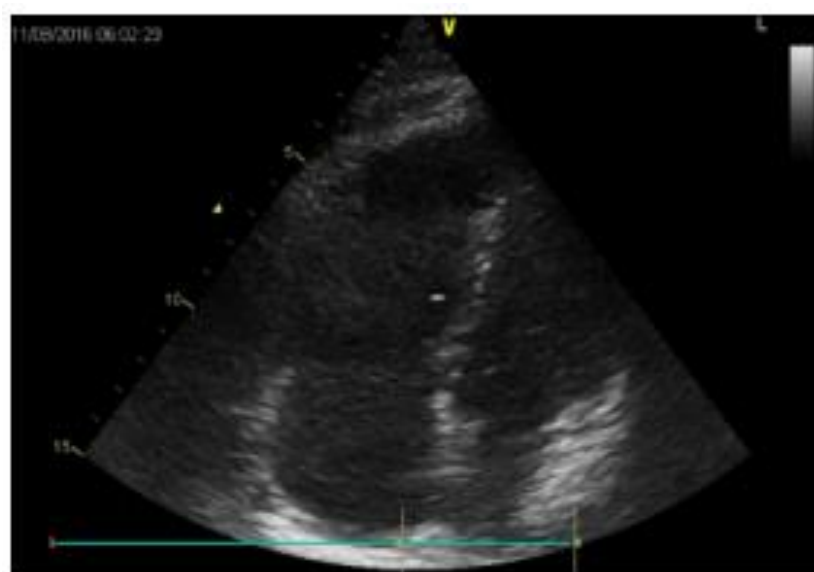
Transthoracic cardiac ultrasound - flattening of the interventricular septum
